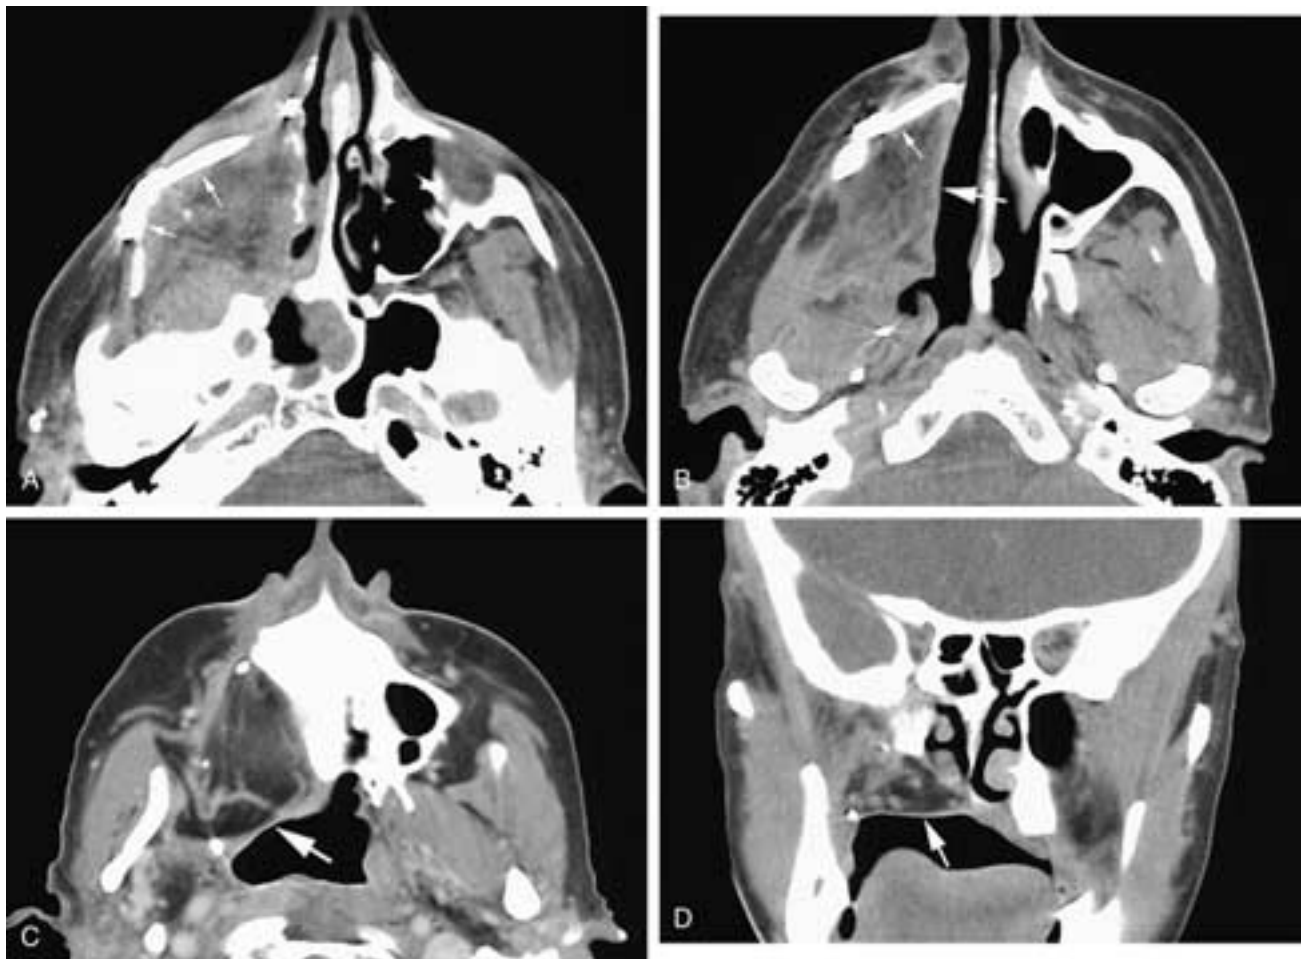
Serial axial CT scans from cranial (A) to caudal (C) and a coronal CT scan (D) on a patient who has had a right total maxillectomy with a graft reconstruction. Plated bone (*small arrows*) is present superficially to give a better contour to the cheek. The fat of the graft fills most of the postoperative cavity and forms the right side of the reconstructed palate. Notice that the free margins of the graft (*large arrows*) are smooth, with a thin mucosal lining. This is the expected normal postoperative appearance for such an operation.
